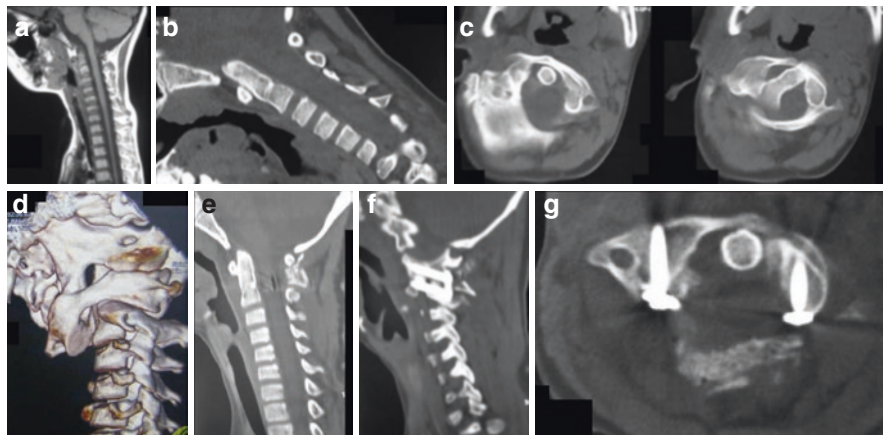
Images a 12-year-old female patient showing rotatory atlantoaxial dislocation. (a) T1-weighted MRI showing abnormal tilt of the odontoid process with no change in atlantodental interval. (b) Sagittal cut of CT showing abnormal alignment of the odontoid process with no change in atlantodental interval. (c) Axial view of the CT scan showing rotatory dislocation. (d) 3D reconstructed view of CT showing the rotatory dislocation. (e) Postoperative CT scan showing reduction of the tilt of odontoid process. (f) Sagittal image of the CT scan showing fixation of the facets of atlas and axis in reduced position. (g) Axial CT scan showing screws passing through the facets of atlas. Reduction of the dislocation can be observed
